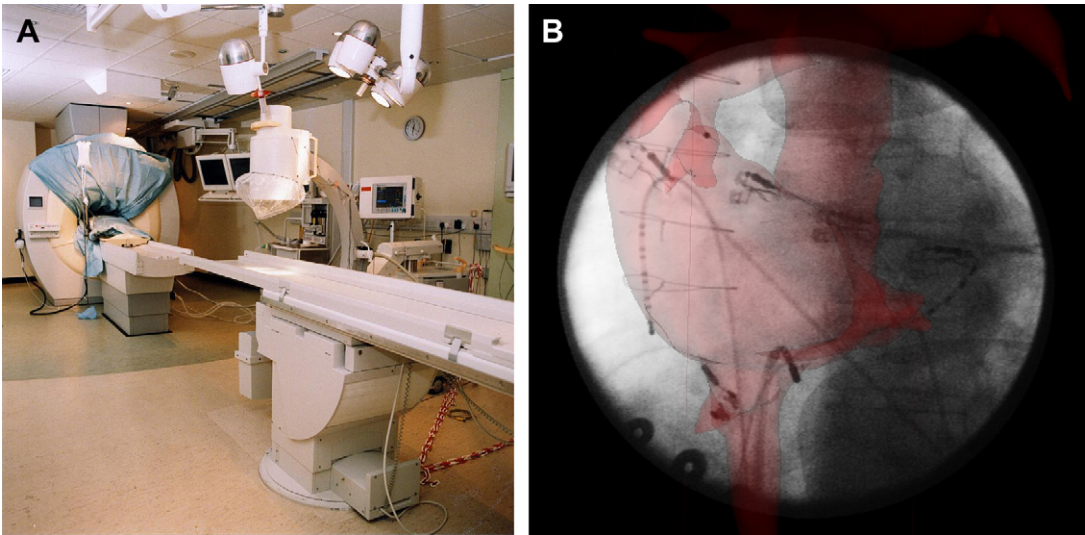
(A) XMR suite with the MR scanner and the X-ray C-arm. (B) Catheters in place during an atrial flutter ablation and overlay of the MR-derived anatomy (in red) of the right side of the heart.
